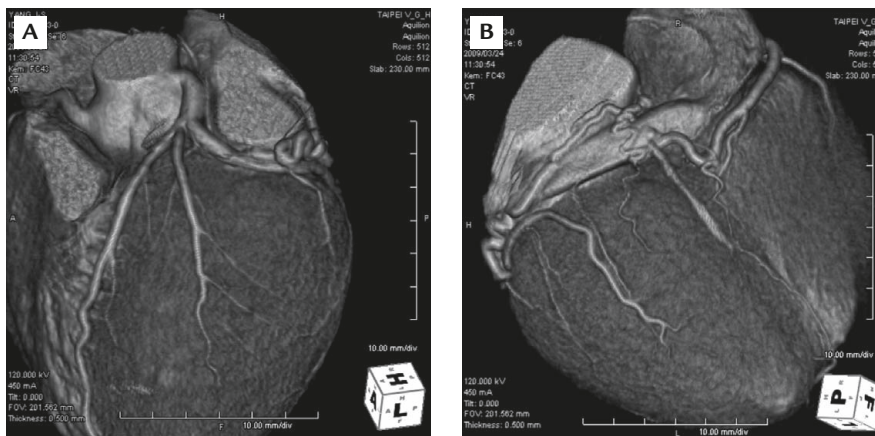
Three-dimensional multidetector computed tomography shows coronary artery fistulas from the left circumflex and right coronary artery to the coronary sinus: (A) left anterior oblique view; (B) posterior view.
